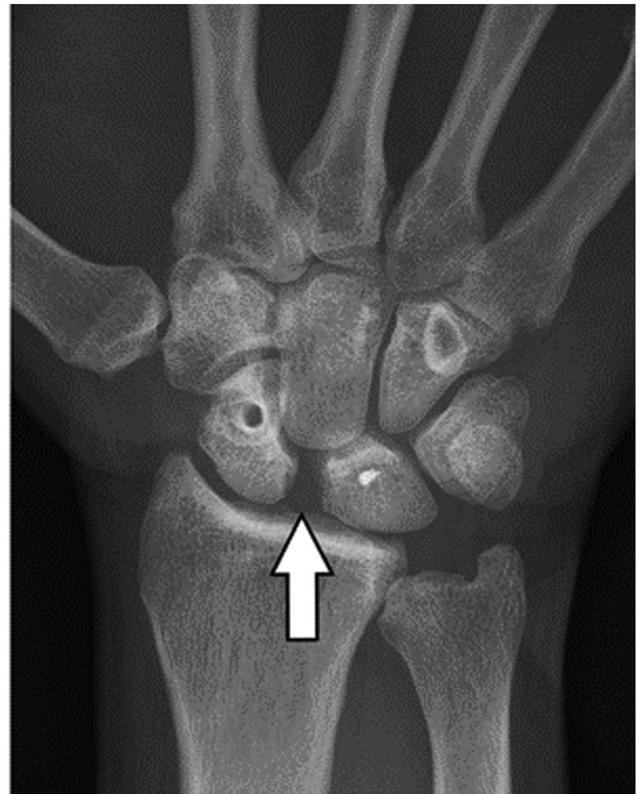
MBR in a 42-year-old salesman with stage 3 chronic SLL injury. Preoperative posteroanterior radiography showed a widened scapholunate interval of 6 mm and DISI deformity. A Posteroanterior radiograph 10 weeks after surgery shows a scapholunate interval of 2.5 mm (arrow). B Posteroanterior radiograph 7 months after surgery shows a scapholunate interval of 4 mm (arrow). Postoperative widening of the scapholunate interval can occur over time after reconstruction and does not definitely indicate graft failure. The patient was asymptomatic over the scapholunate ligament with no instability at clinical examination. (Adapted with permission from Palisch et al¹⁰¹).
